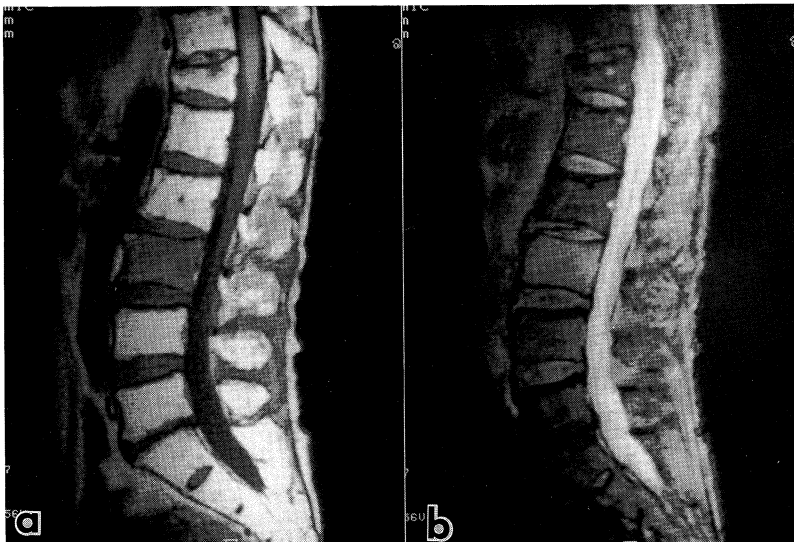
Midline sagittal MR images of vertebrae. A T1-weighted spin echo image (420/25) (a) shows diffusely decreased signal intensity and a T2*-weighted gradient echo image (480/30, FA : 25°) (b) shows mildly increased signal intensity. Benign vertebral collapse of Th12 is also noted.
